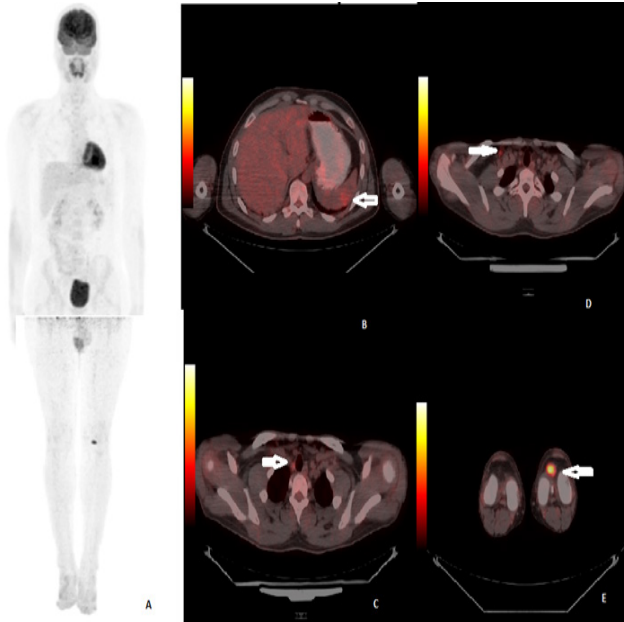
Interim PET/CT scans after 2 cycles of first-line treatment: A) MIP images, B) splenic lesion, C-D) lymph nodes, E) focal patellar uptake (white arrows).
